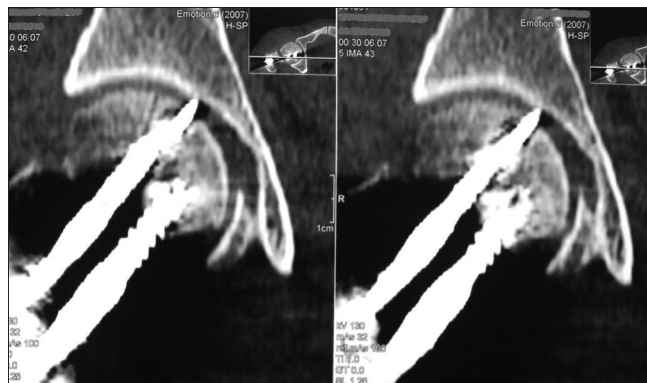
3 mm cuts of computed tomography, coronal images, showing wire-tip protrusion into the hip joint
